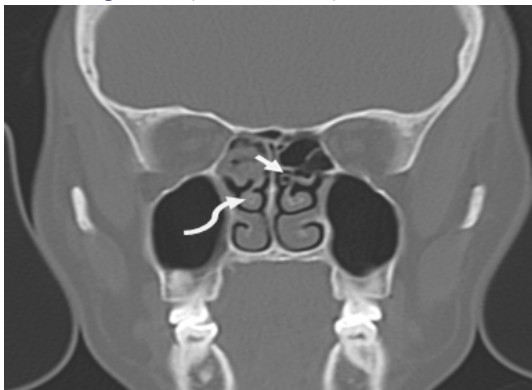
CT scan PNS coronal section showing paradoxical curvature of right middle turbinate (curved arrow) and accessory middle turbinate on the left side (small arrow).
